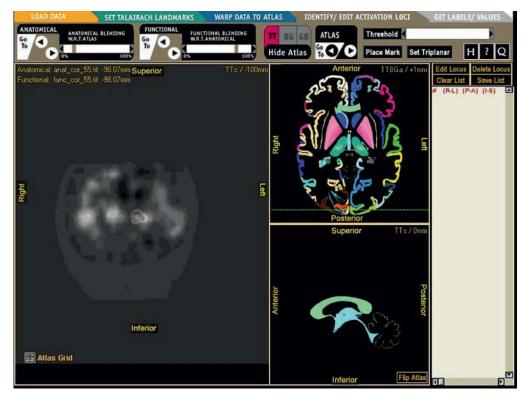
Also taken from the Brain Atlas for Functional Imaging (BAFI) (Nowinski and Thirunavuukarasuu 2000). Image shows a coronal image from a functional MRI series which has been coregistered into the Taliarach coordinate system. The *right panels* indicate the position of the marker point on the atlas and the *far right panel* gives a coordinate description of the areas of activation
